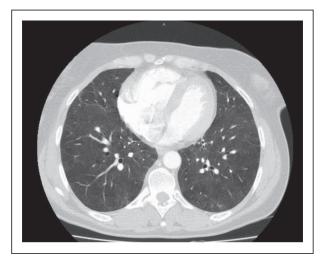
High-resolution computed tomography scan of a 38-year-old woman with acute hypersensitivity pneumonitis. The image shows extensive ground-glass opacities.
